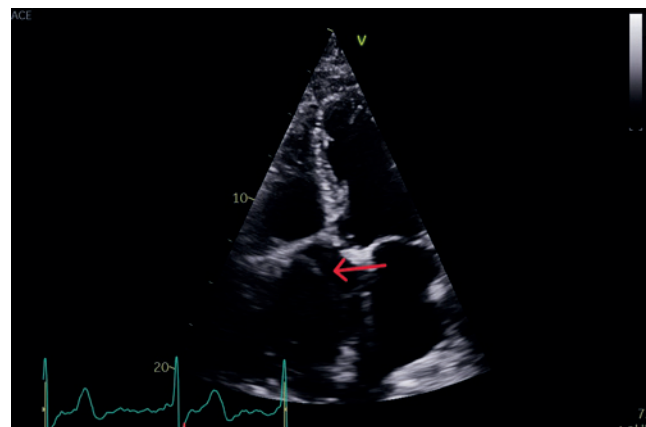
Apical five-chamber view showing an echogenic portion of the ascending aorta
